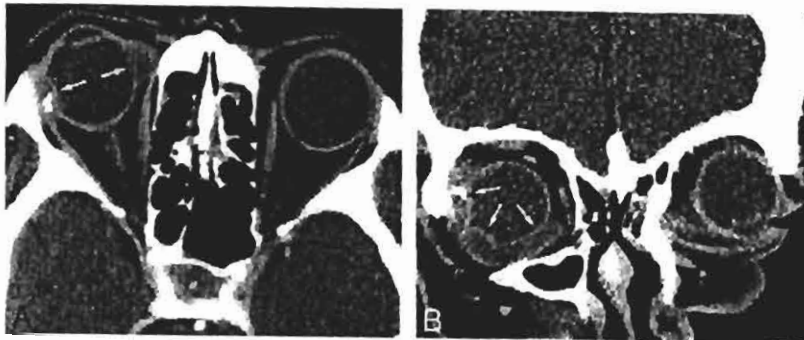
Case 3. A and B, Contrast-enhanced axial (A) and coronal (B) CT scans show circumferential soft tissue mass surrounding the globe with focal, dystrophic calcification and a peripherally enhancing rim (arrows).
